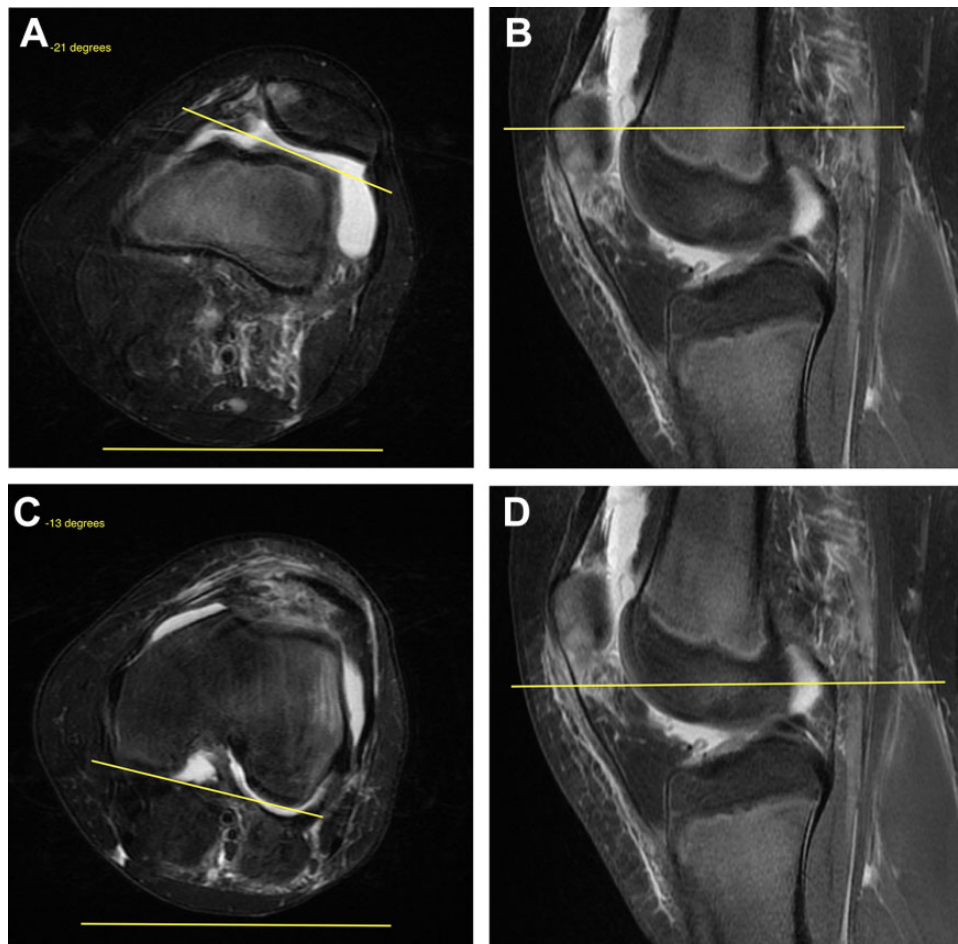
(A) Axial MRI image of knee showing the most proximal cut of trochlear cartilage. An angular measurement is made of the trochlear cartilage relative to the horizontal. In this case, because the angle slopes up medially (convex trochlea), it is recorded as a negative number: -21° . (B) Sagittal MRI image of knee with cross-reference lines that help the viewer identify the most proximal cut of trochlear cartilage on the axial image. The sagittal image that has the most proximal extent of visible trochlear cartilage was chosen. This tended to be just lateral to the intercondylar notch. (C) Axial image showing fully formed posterior femoral condyles. An angle is measured here between the posterior condyles and the horizontal. Angular measurements that show internal rotation are recorded as positive values. Because the condyles are externally rotated in this image, the angle here is -13° . The LTI is calculated by subtracting the angle of the posterior condyles from the angle of the proximal trochlea; in this case, it is $-21^\circ - (-13^\circ) = -8^\circ$. (D) Sagittal MRI image of knee showing the level at which the posterior femoral condyles are fully formed. Note the distance between the proximal trochlea and the fully formed posterior condyles. LTI, lateral trochlear inclination; MRI, magnetic resonance imaging.
